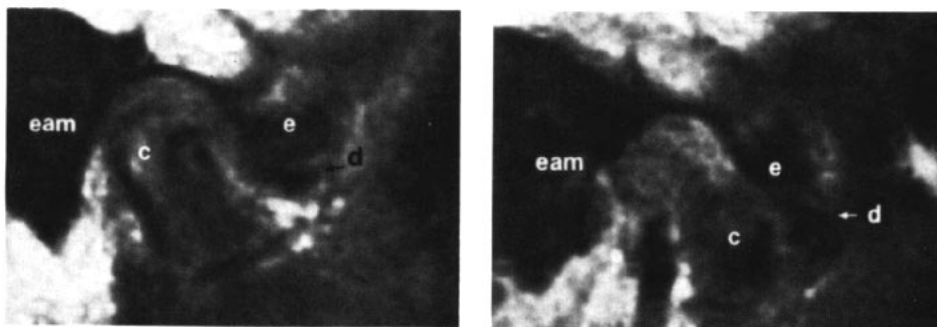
MRI of anterior disc displacement without reduction. Condyle (c) and eminence (e) are seen as intermediate intensity or gray structures, due to partial image sectioning through both cortical bone and marrow.
